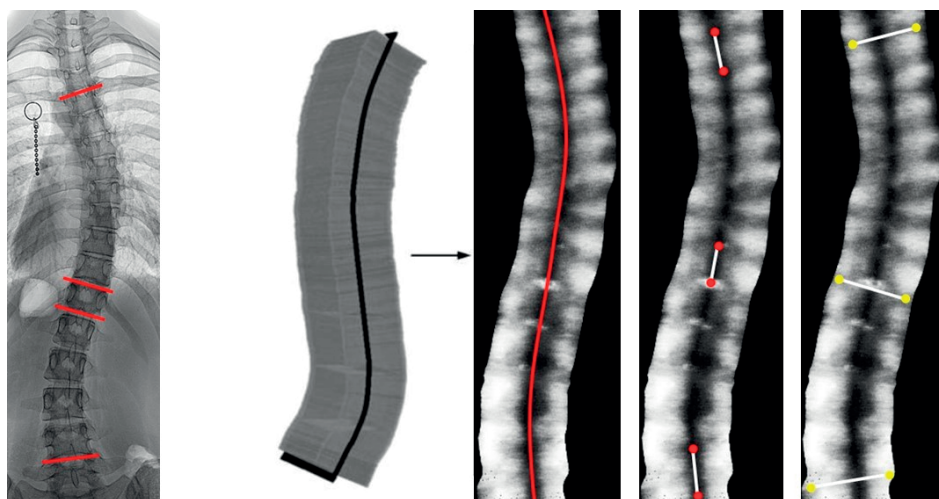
In chapter 11, the Cobb angles, as measured on the radiographs, were compared with the different ultrasound angles, as measured on the reconstructed coronal image.
